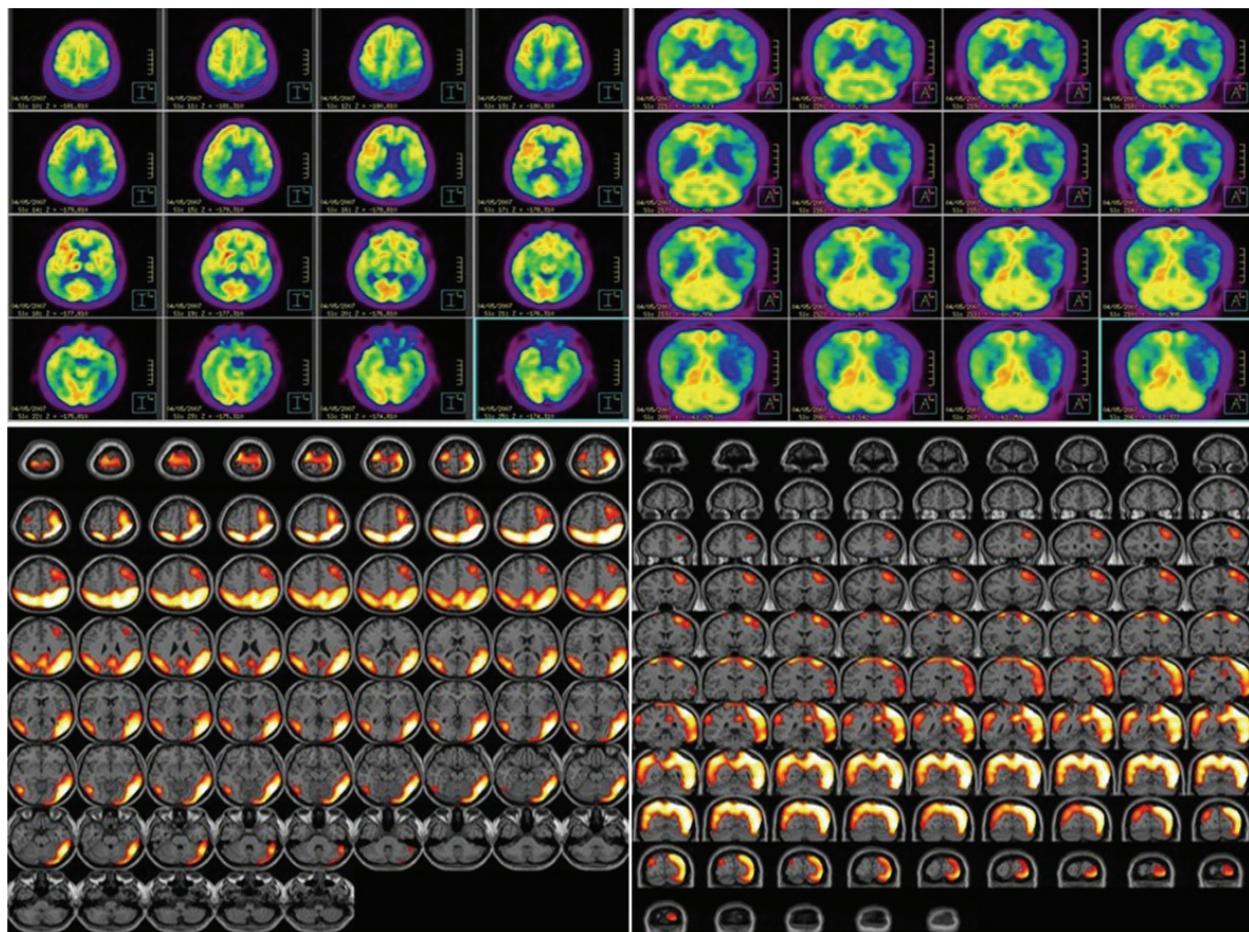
Brain FDG-PET imaging with SPM analysis showing prominent asymmetric (left-dominant) hypometabolism on both parietal and left temporal areas. Significant hypometabolism was also observed in both frontal lobes.
